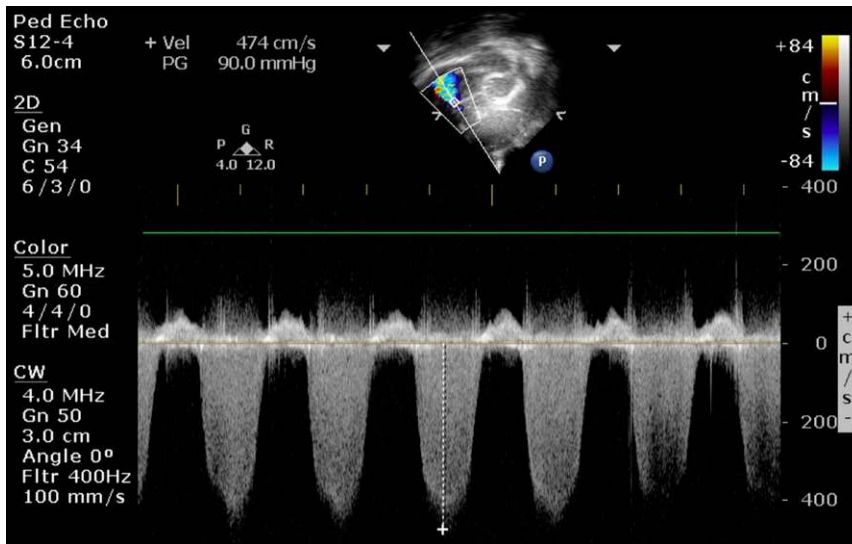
Continuous-wave Doppler across the tricuspid valve in this parasternal short-axis view at the level of the base measuring the peak regurgitant velocity. The velocity can be incorporated into the modified Bernoulli equation to quantify RV pressure.
